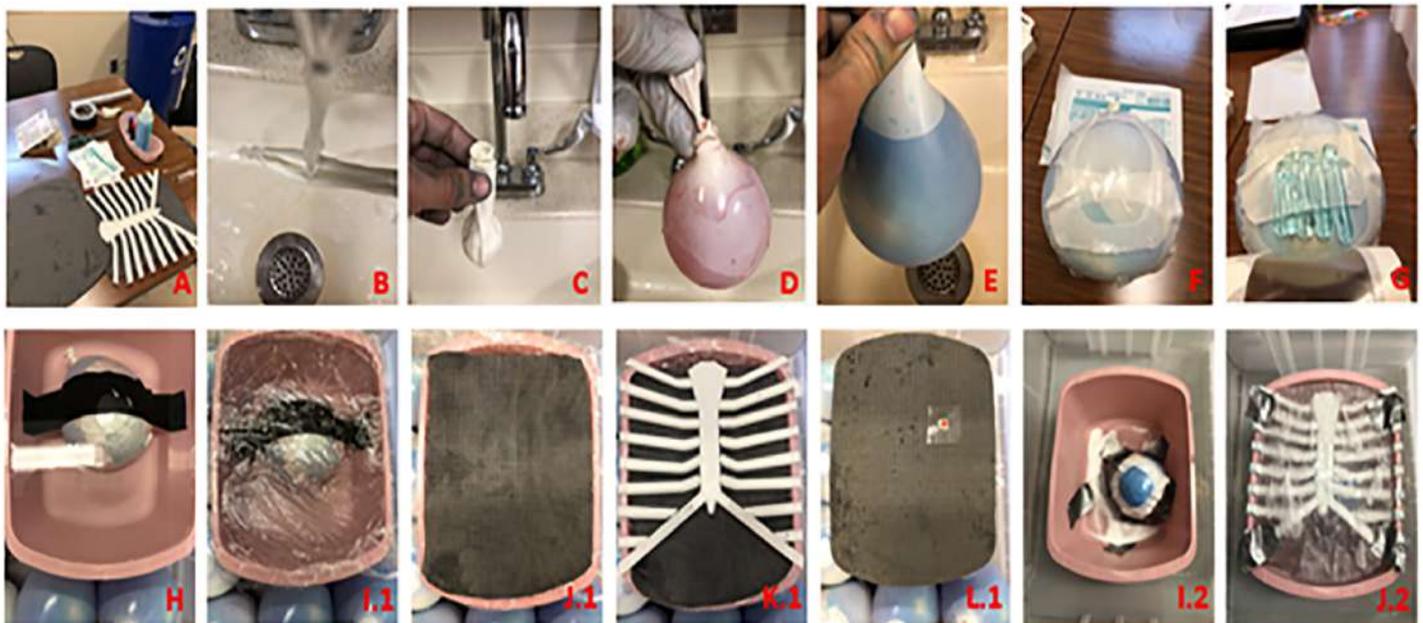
Design step-by-step progression: A. All supplies minus wash basin. B. Run warm water on the inner balloon over a blunt knife. C. Pass balloon inside outer balloon using knife. D. Place a drop of red food coloring and fill the inner balloon. E. Place a drop of blue food coloring and fill the outer balloon. F. Place a layer of Tegaderm on the outer balloon. G. Add a layer of ultrasound gel between layers of Tegaderm. H. Tape balloon to bottom of dry water basin. I.1. Place a layer of plastic wrap. J.1. Place the first layer of ¼" yoga mat. K.1. Clip on anterior chest variant 1 to water basin. L.1. Place the second layer of ¼" yoga mat and add the left shoulder indicator to the mat. I.2. Add polyethylene glycol (or equivalent). J.2. Tape a layer of parchment paper over the anterior chest variant 2 and fill the water top of basin.
